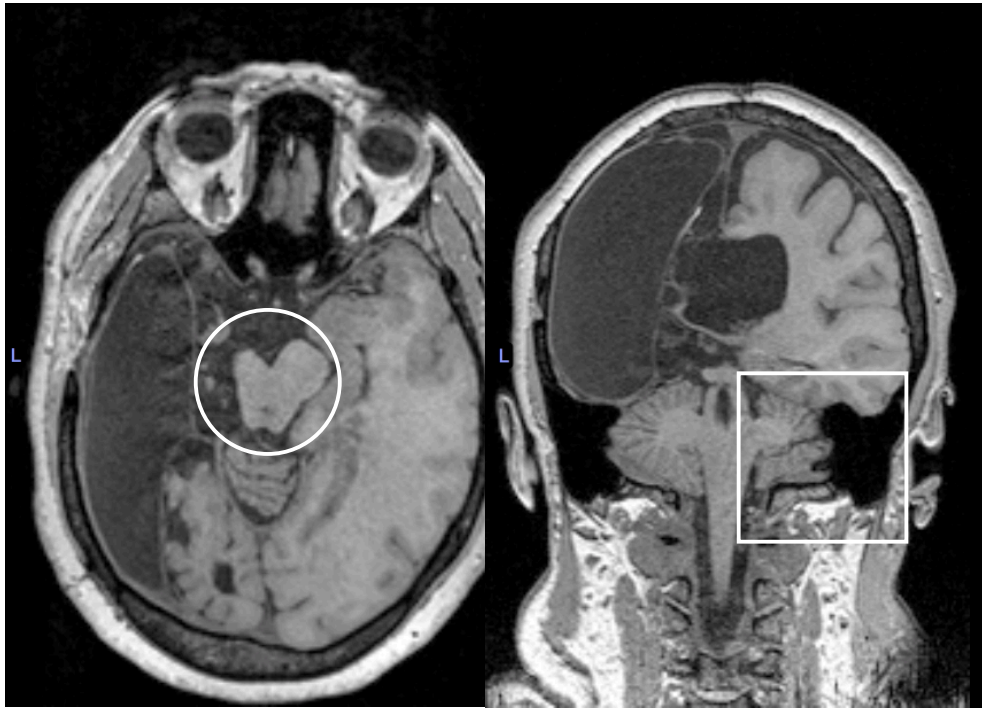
T1-weighted MRI: E.B.
